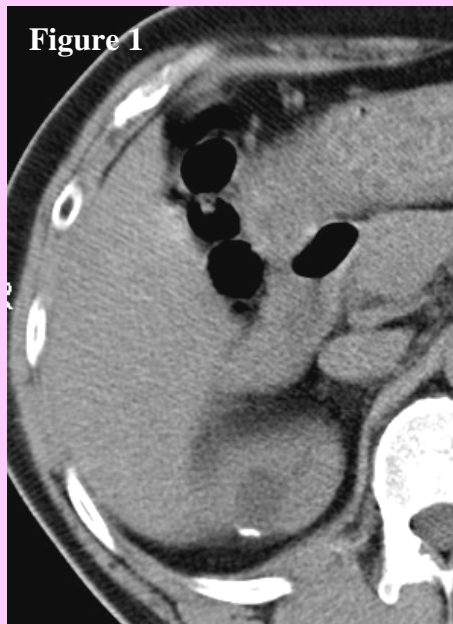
Pre-contrast axial CT. Figure 2: Arterial phase axial CT. Arrow = Hepatocellular carcinoma.
